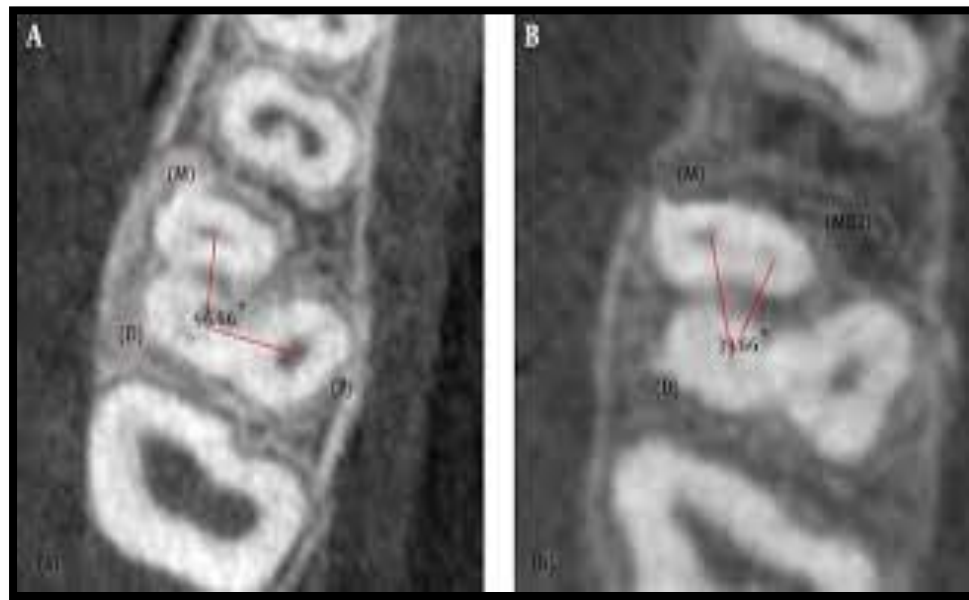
Location of MB2 canal with CBCT
